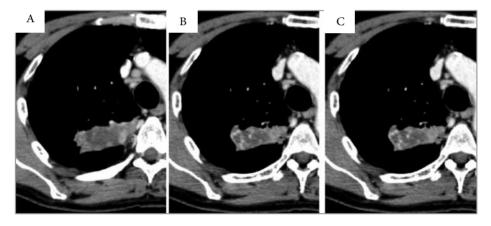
Chest CT scan 22 weeks after the initiation of nivolumab therapy (before systemic corticosteroid therapy) (A). Chest CT scan at 6 weeks after the initiation of systemic corticosteroid therapy (30 weeks after initiation of nivolumab therapy) (B). Chest CT scan at 10 weeks after the initiation of systemic corticosteroid therapy (34 weeks after initiation of nivolumab therapy) (C).
